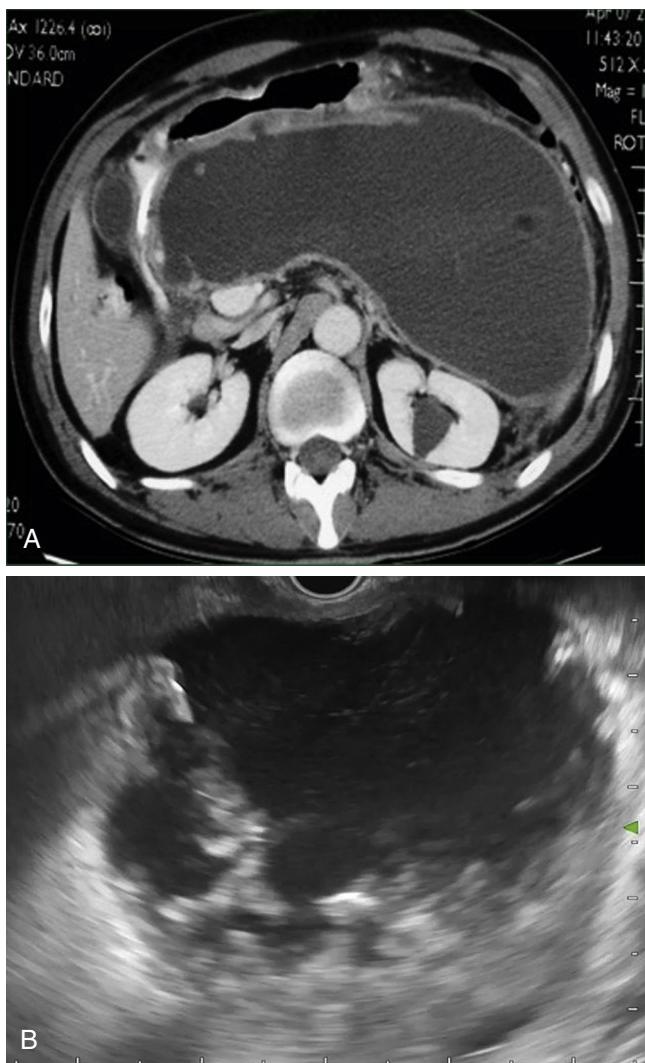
(A) Axial computed tomography image of an acute necrotic collection. (B) Acute necrotic collection on endoscopic ultrasonography: this is characterized as an ill-defined fluid collection lacking a definitive wall.
